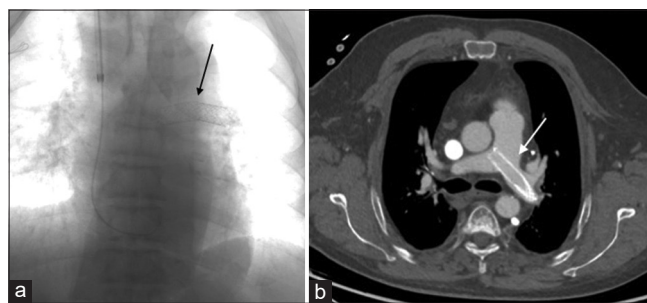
(a) A 52-year-old patient with the right brachiocephalic and proximal superior vena cava (SVC) stenosis treated with two over-balloon stents, which migrated to the left pulmonary artery. Fluoroscopy showing the dislodgement of the stents into the main pulmonary trunk and the left pulmonary artery (arrow). (b) A 52-year-old patient with the right brachiocephalic and upper SVC stenosis treated with two over-balloon stents, which migrated to the left pulmonary artery. Axial CT scan of the chest with contrast showing the migrated stents located in the main pulmonary trunk and the left pulmonary artery (arrow).
